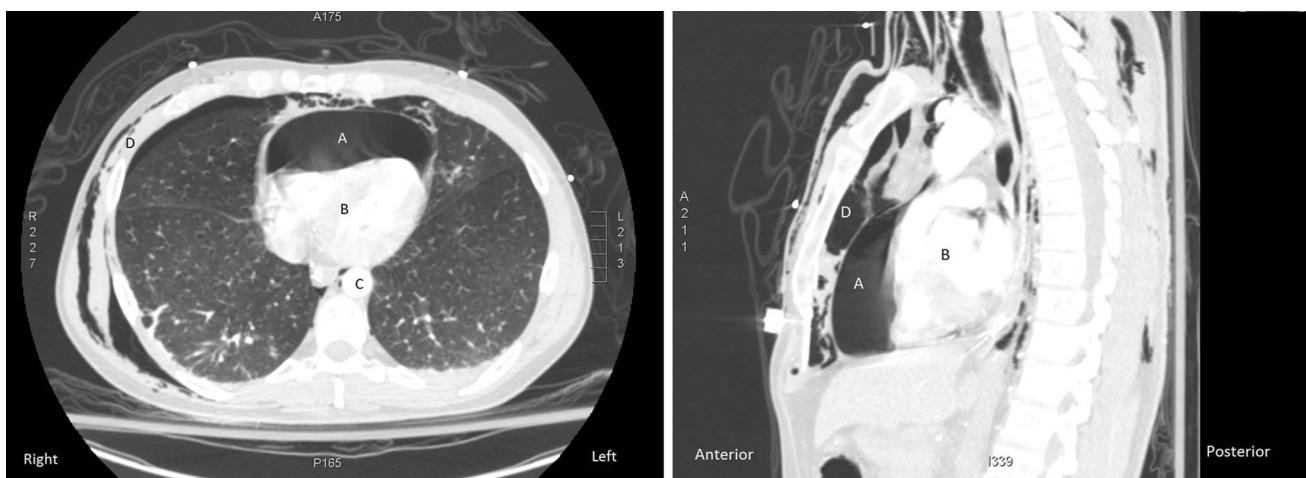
Figure Transverse and sagittal thoracic computed tomography images show evidence of massive pneumopericardium (A) anterior to the heart (B) and aorta (C). There is also right-sided pneumothorax and significant subcutaneous emphysema (D)
